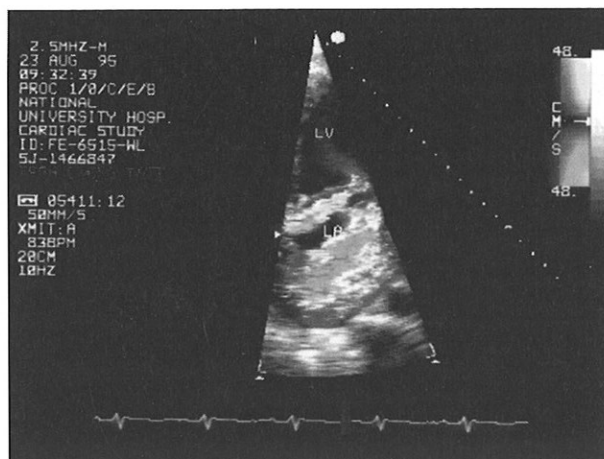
A 40-year-old Chinese male with a past history of mitral valve prolapse presented with progressive shortness of breath. This apical 4 chamber view shows severe mitral regurgitation.
